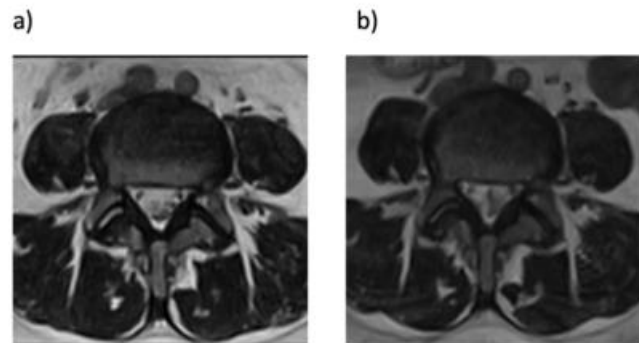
Axial MRI in clinostasis (a) and orthostasis (b) position in patient with spinal stenosis below the spinal stenosis.
